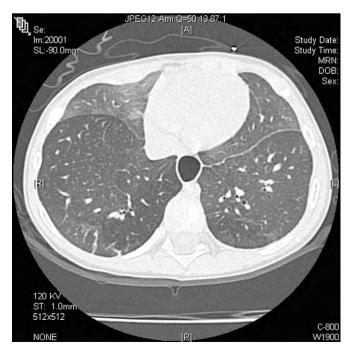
High resolution CT scan of lungs of a young child with neuroendocrine cell hyperplasia. Note the patchy nature of the ground-glass appearance characteristic of this condition.
